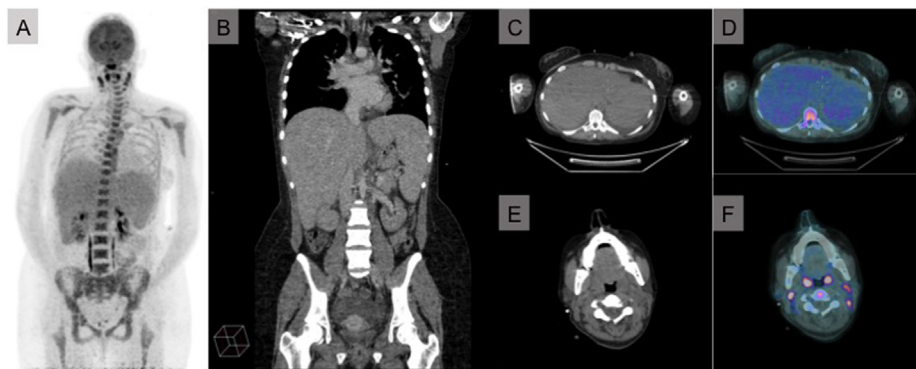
Images from 18F FDG PET-CT. A. Maximum intensity projection (MIP) showing significant hepatosplenomegaly. B. Coronal view CT showing significant hepatosplenomegaly. C. & D. Axial view CT + 18F FDG PET-CT showing significant hepatosplenomegaly. E. & F. Axial view CT + 18F FDG PET-CT showing enlarged deep upper cervical lymph nodes.
